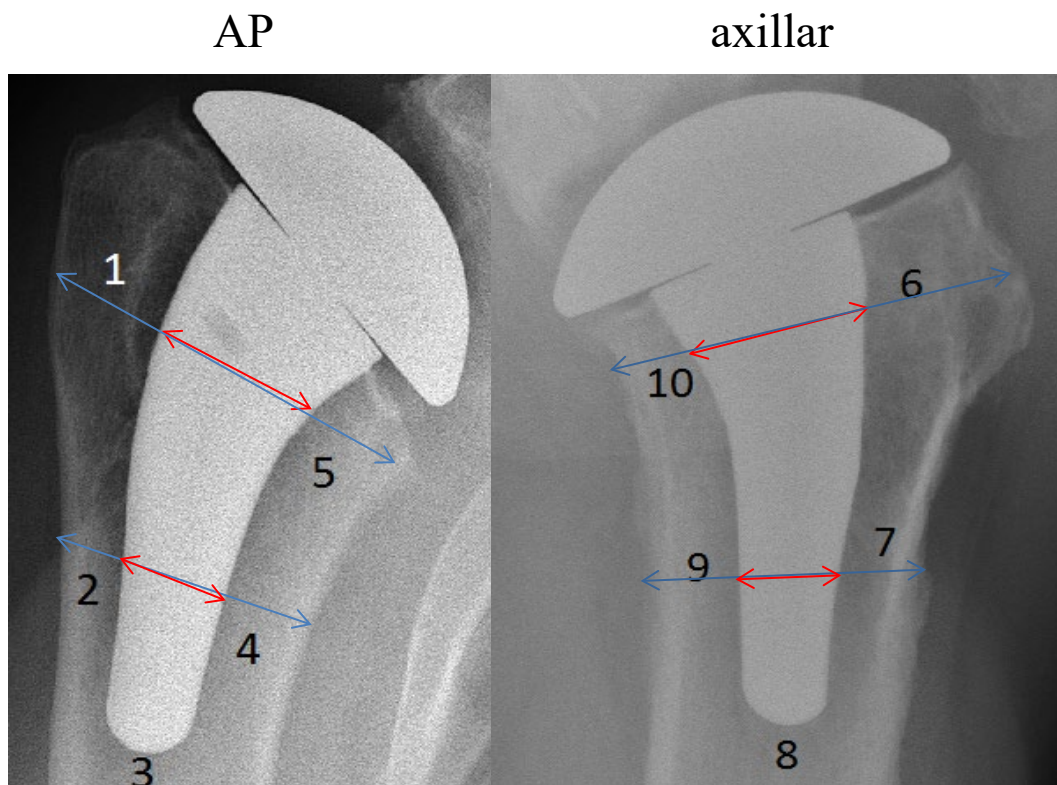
The method of determining the filling ratio in 2 x-ray planes. The mean average of the 4 ratios (red/blue) is taken.
